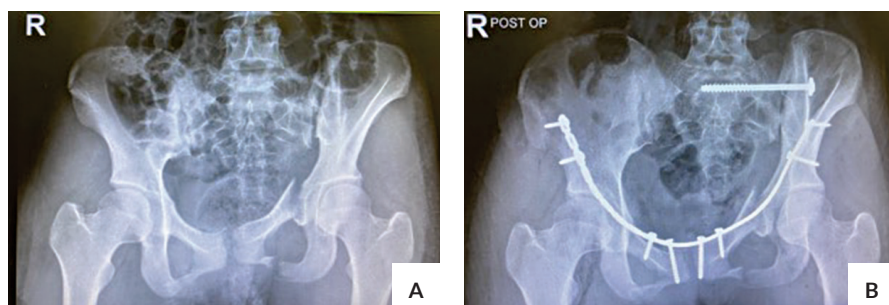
Radiographs from Patient 10 – Female, 20-year-old, car accident. (A) Pre-operative lateral compression injury, (B) Immediate post-operative.
